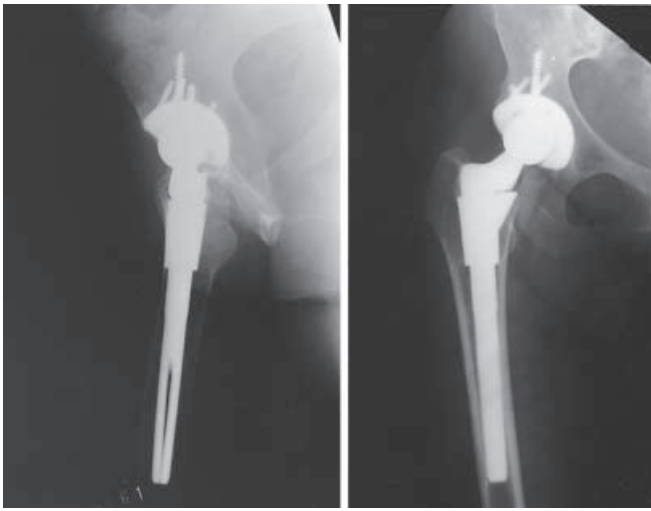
Radiographs of the right hip 1 year after surgery. The fused hip was converted to a cementless arthroplasty using the S-ROM system. The radiographs show no loosening or clear zones around the hip
